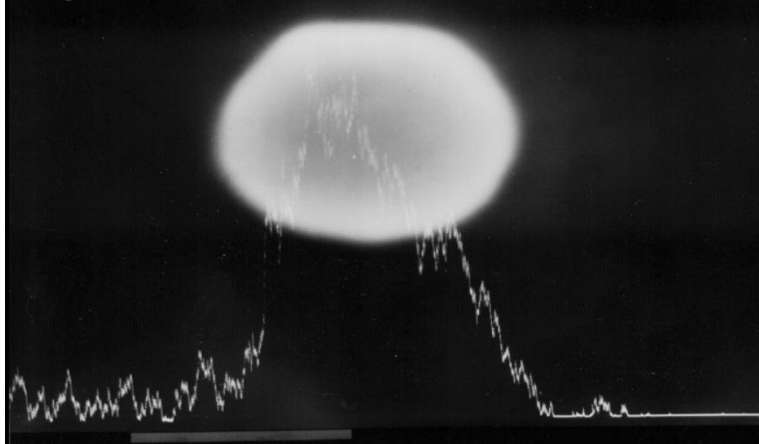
Amalgam gas in x-rays [25]
